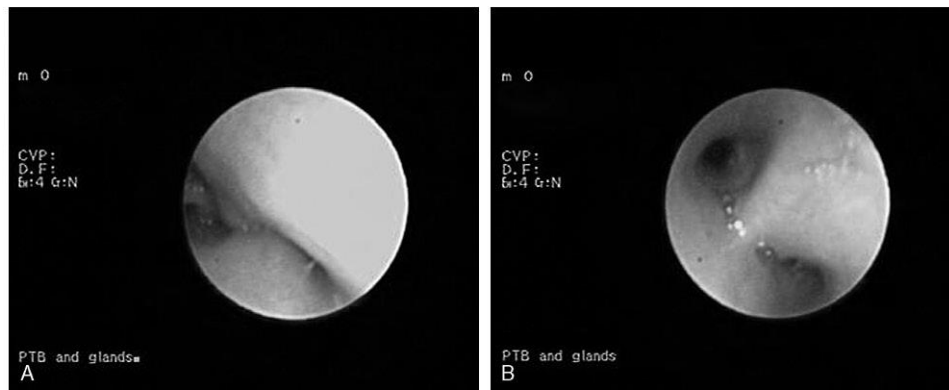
Bronchoscopic pictures (A) before and (B) after surgical transthoracic enucleation of nodes.
